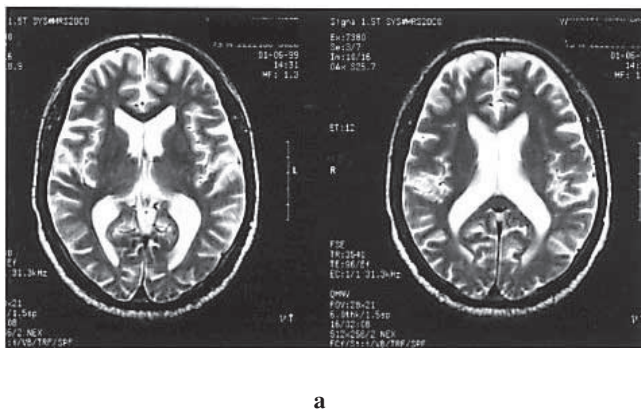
MR study in a 73-year-old male with transient ischemic attack (TIA). (a) MRI (T2-WT) shows almost normal image. (b) MR-angiography shows severe stenosis of the left IC.
